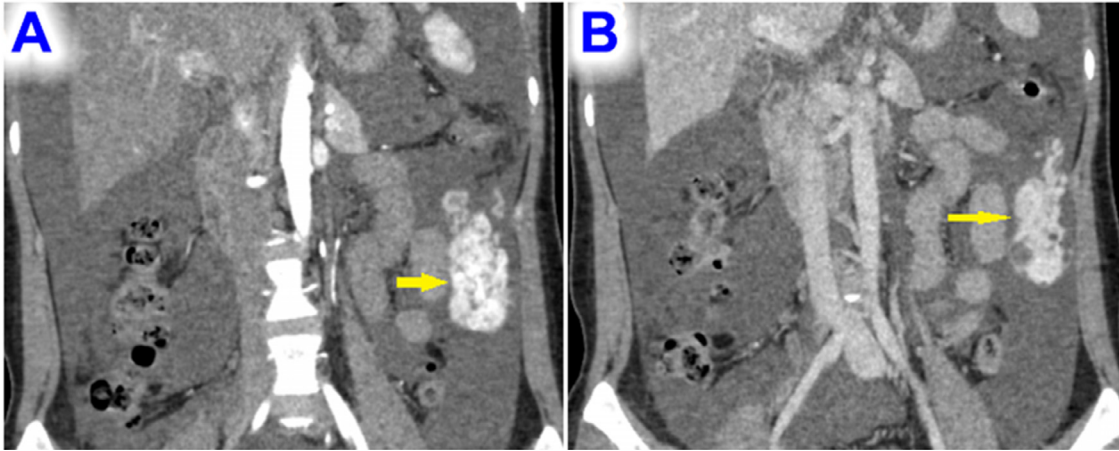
Retroperitoneal STF in the CT scan. Axial and coronal contrast-enhanced computed tomography images showing a well-defined mass (long arrows) in the left lumbar region, with vivid and homogenous enhancement in both the (A) arterial phase and the (B) venous phase. Large volumes of free intra-abdominal fluid were also observed.
